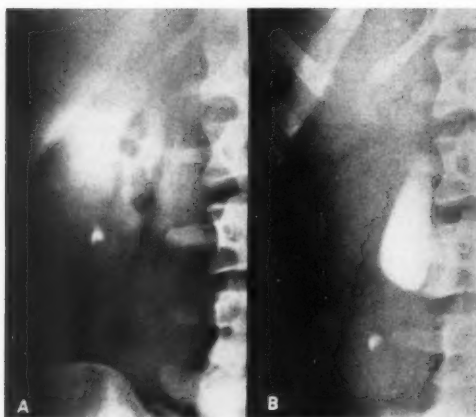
Roentgenograms of the right kidney of an asthenic woman with a calcific concrement in the inferior calyx.
